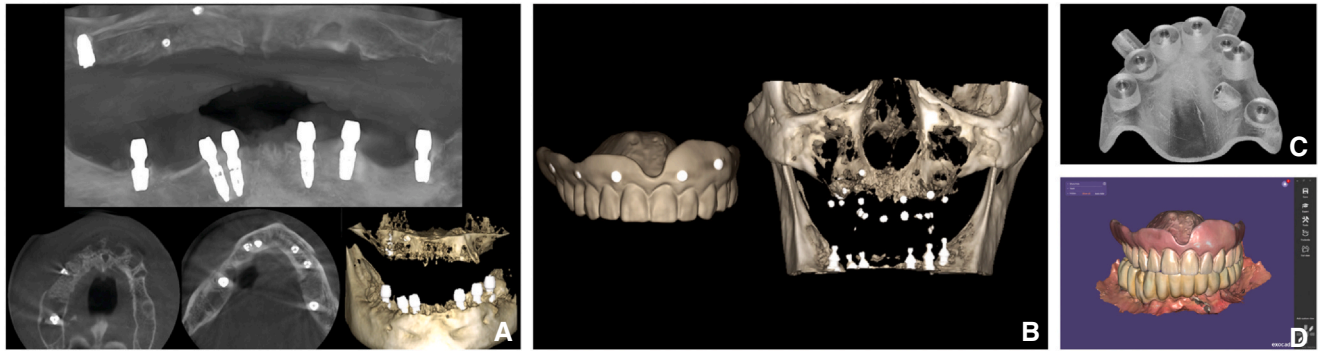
Treatment planning procedures phase 2. A, CBCT scan after sinus elevation and grafting procedures. B, Double CBCT scan method. C, Surgical implant guide. D, Intraoral scans after healing of first surgical and restorative phase 1: extraoral scan of maxillary interim CD and mandibular interim prosthesis. CBCT, cone beam computed tomography; CD, complete denture.
